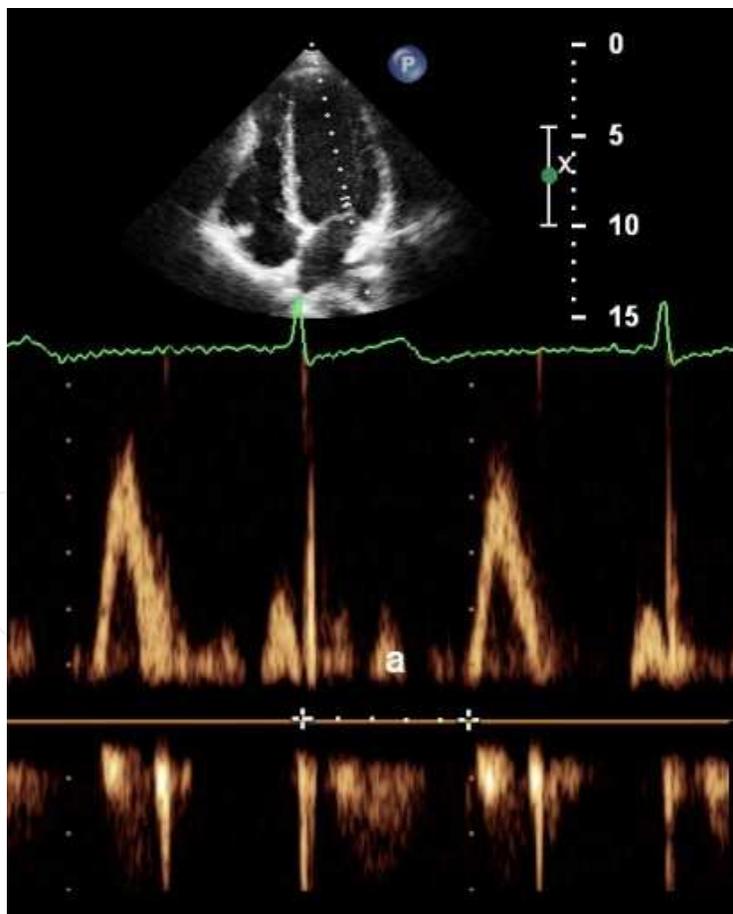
Measurement of interval (a) which includes the isovolumic contraction time, ejection time and the isovolumic relaxation time. The spectrogram is registered with PW-Doppler at the tips of mitral valve leaflets from apical 4-chamber view.
